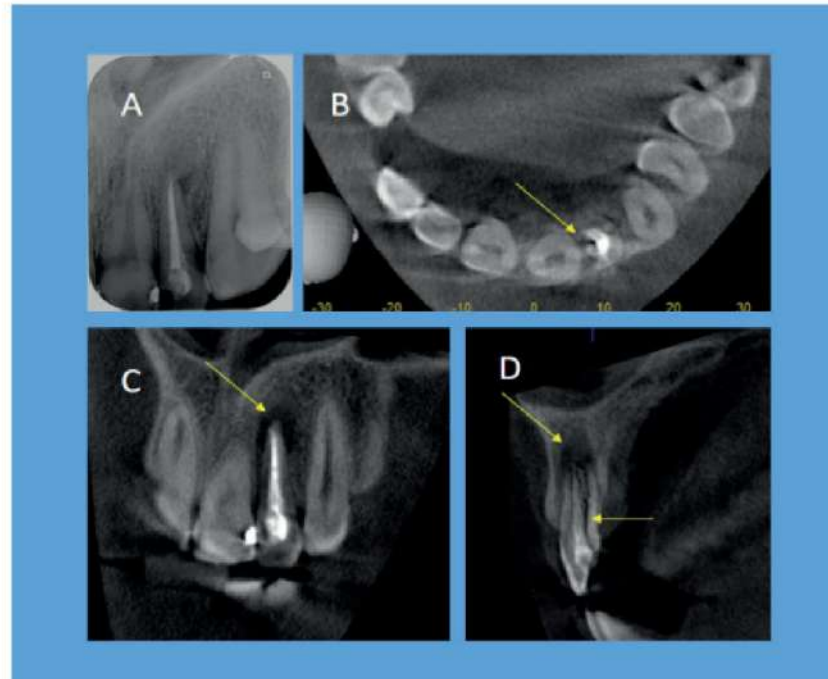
Periapical radiograph (A) showing root canal treated maxillary left lateral incisor without any significant changes. In the CBCT, axial (B), coronal (C) and sagittal (D) view showing periapical lesion with vertical root fracture (Yellow arrow).
